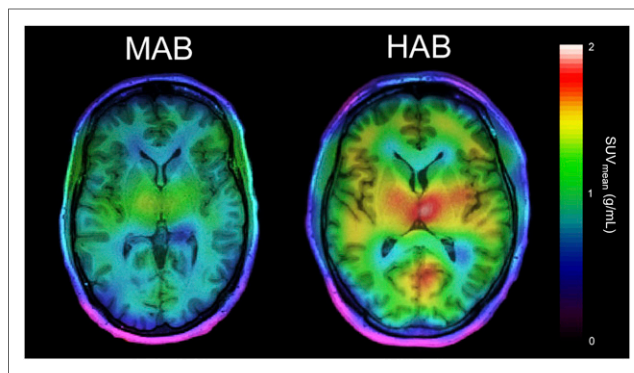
Brain SUV_{mean} of typical MAB (subject 12) and HAB (subject 11).
